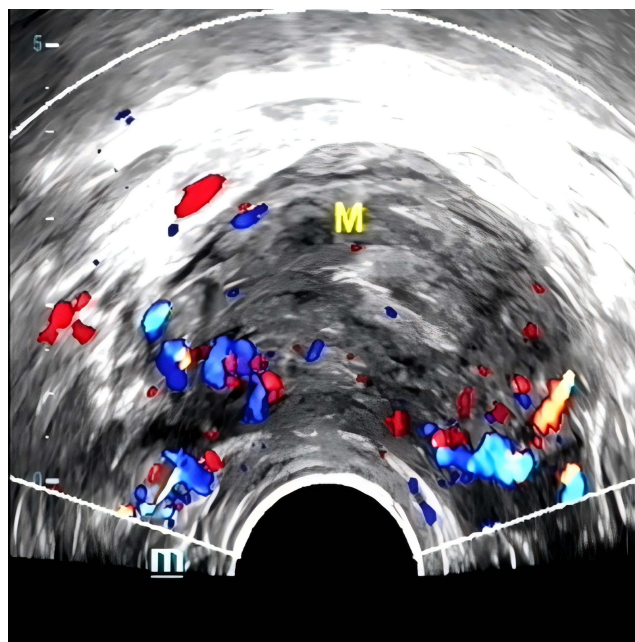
Two months after the completion of all treatments, the patient's ultrasound results showed complete removal of submucosal myoma. The "M" in the [Figure 5](#) represents a leiomyoma.
